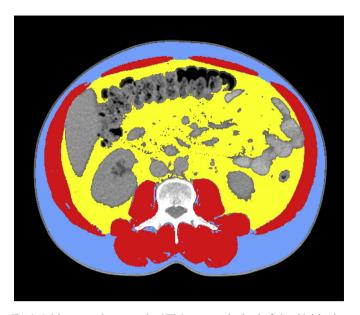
Axial computed tomography (CT) images at the level of the third lumbar vertebrae were analyzed for muscle and fat tissue cross sectional areas and analyzed using an appropriate software. Muscle mass is shown in red and was quantified within a Hounsfield unit (HU) range of -29 to 150, visceral fat shown in yellow, range from -150 to -50 and subcutaneous fat shown in blue range from -190 to 30. Muscle radiation attenuation was calculated for muscle area.
